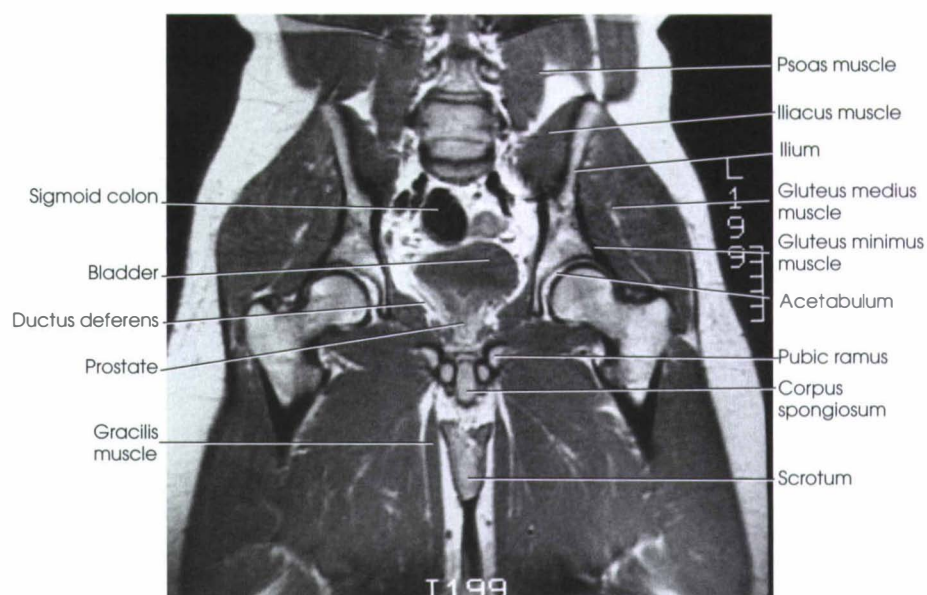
MRI of the abdominopelvic region at the midcoronal plane.
